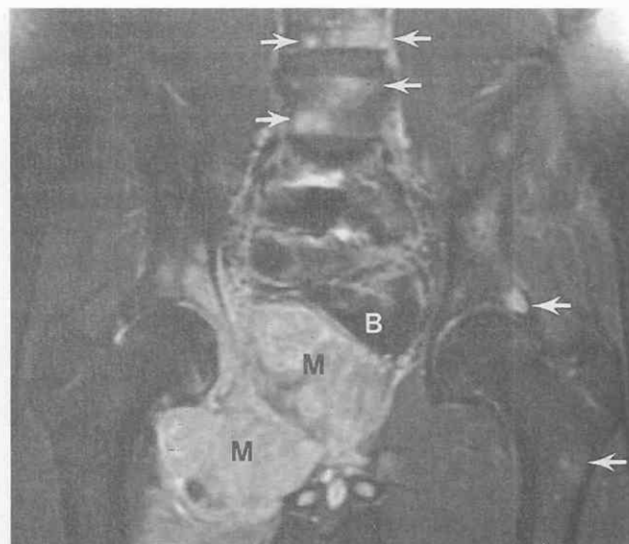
Primitive neuroectodermal tumor arising from the right hemipelvis in a 14-year-old boy. Postgadolinium coronal T1-weighted image (TR = 700 msec, TE = 14 msec) with fat saturation shows the mass (M) to extend into proximal thigh and to displace the bladder (B). The medial right acetabulum is destroyed. Metastatic lesions can be seen within the lower spine, left ilium, and left proximal femur (arrows).
